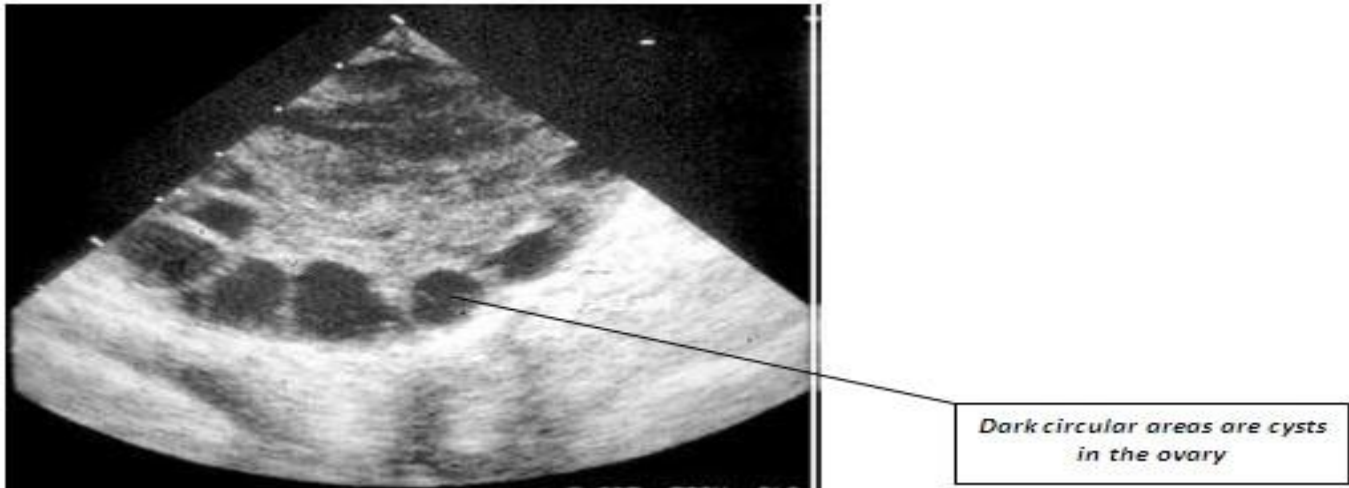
Ultrasound picture of a polycystic ovary
